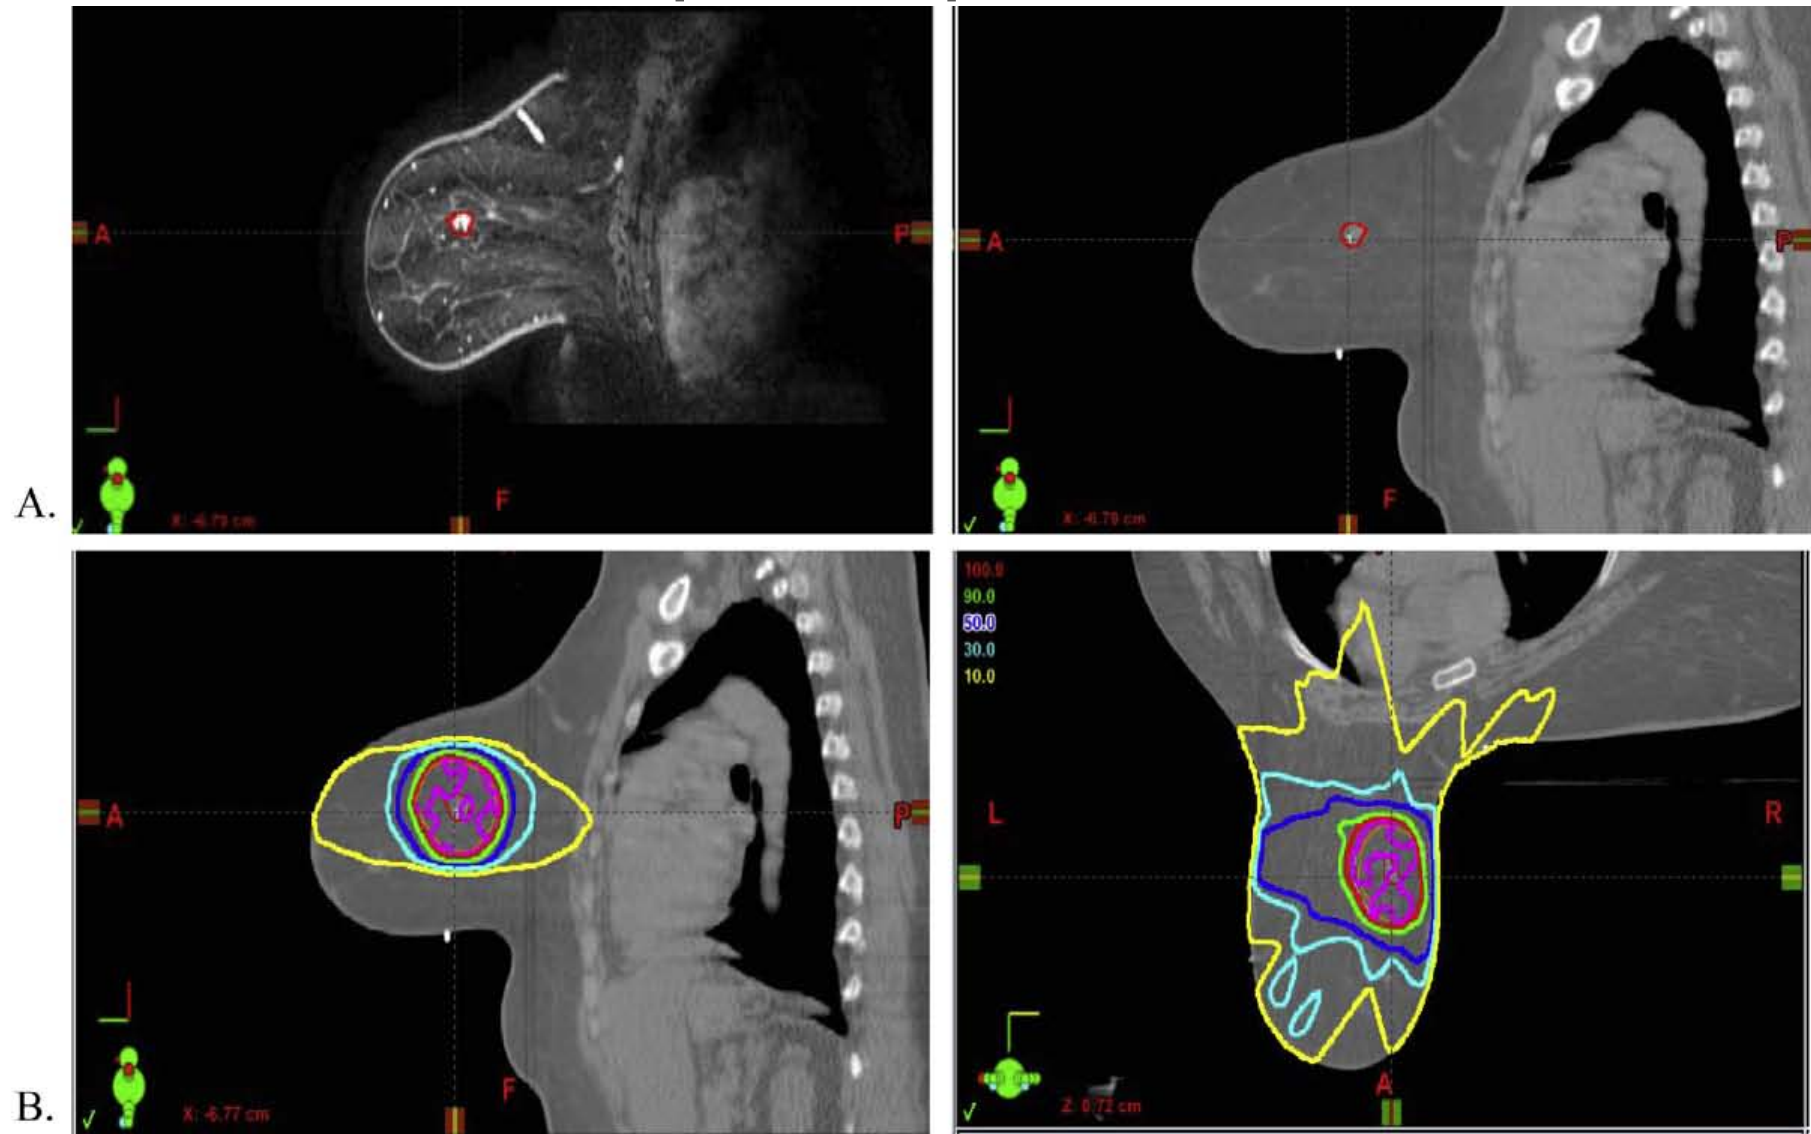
Preoperative radiation to the intact tumor. (A) Sagittal view of a prone treatment planning magnetic resonance imaging scan (left) and computed tomography scan (right). (B) Sagittal (left) and axial (right) treatment planning images with dose distribution in the same patient.
